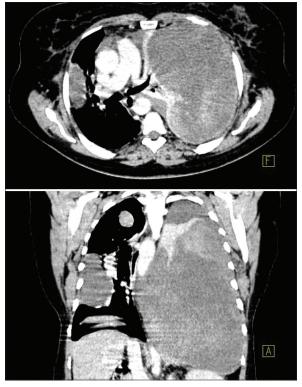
Postcontrast computed tomography scan axial and coronal images show large well-defined lesion in the left hemithorax with collapsed lung medially and smaller similar lesions in the right middle lobe with inhomogeneous mild contrast enhancement
